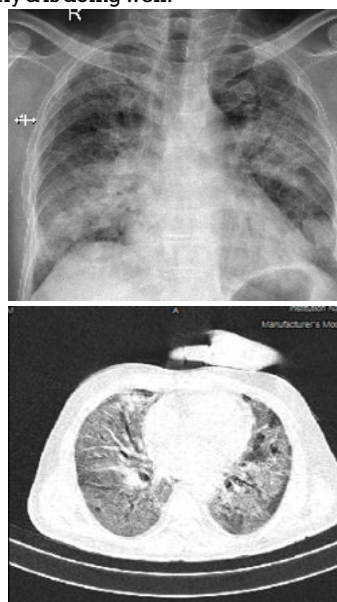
Chest X-Ray showing B/L Opacities
